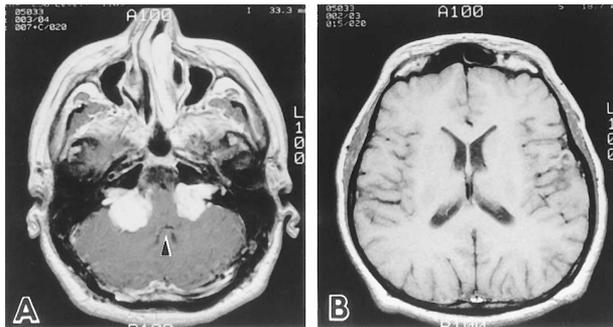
T1-weighted magnetic resonance images with gadolinium enhancement showing bilateral acoustic tumors located at cerebellopontine angle (September 1995). Note fourth ventricle was patent although partially compressed (arrowhead) (A). Lateral ventricles and cortical sulci were normal in size, and obstructive hydrocephalus was not evident (B).
